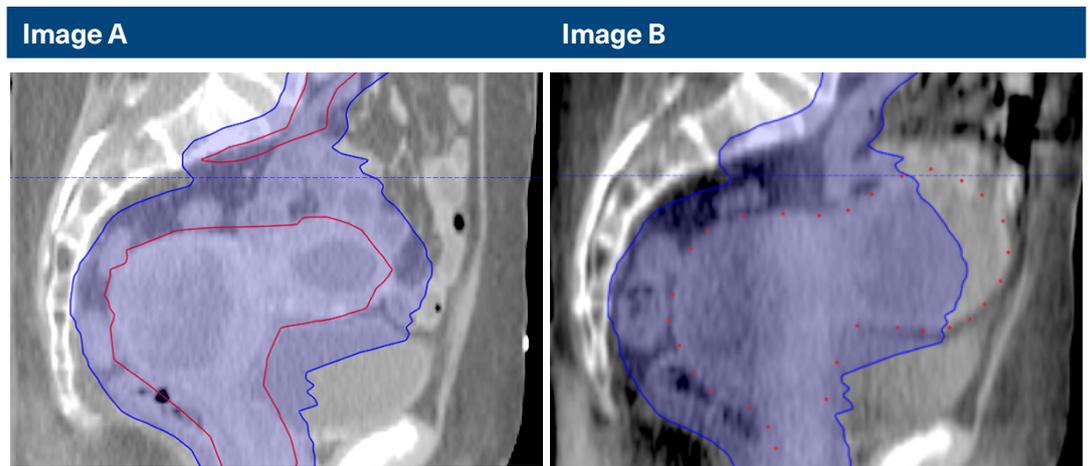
fraction 4 CBCT. The PTV is outlined in blue, CTV in red. Note the anterior shift due to an increase in rectal diameter.
